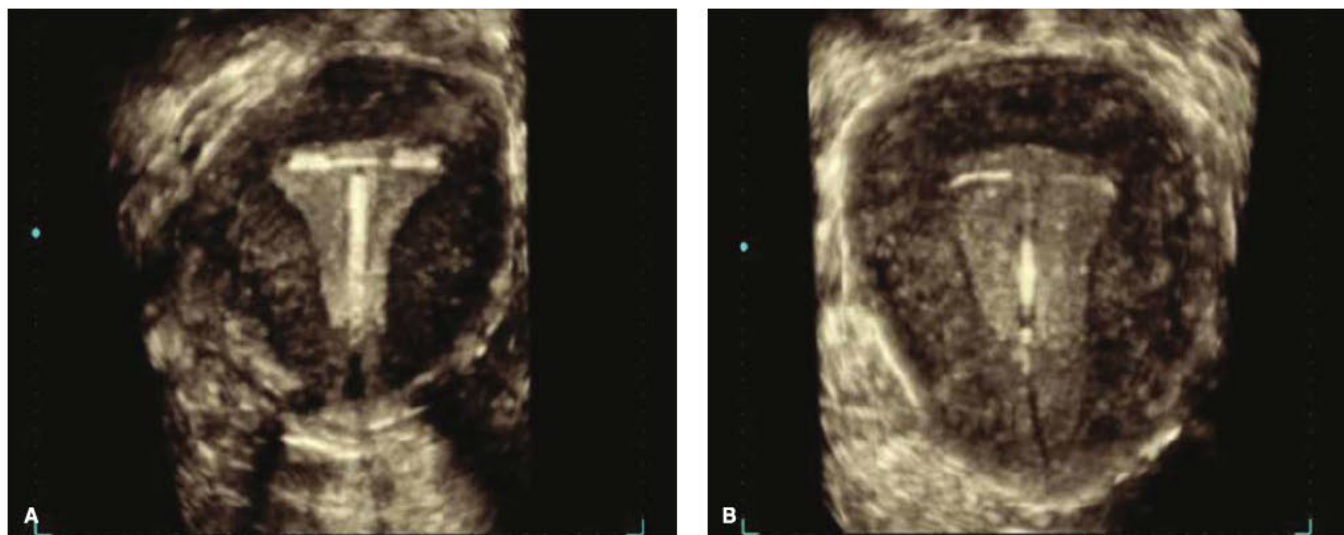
Intrauterine devices (IUDs). The coronal planes of 3-dimensional sonography best depict the type and positioning of the Copper T 380A IUD (ParaGard) (A) and levonorgestrel-containing IUD (Mirena) (B) within the endometrial cavity.
